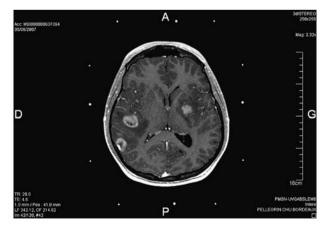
Secondary lymphoma: multiple deep-seated lesions (T1-weighted sequences after IV Gadolinium infusion) in a patient suffering extranodal lymphoma diagnosed 4 years ago
